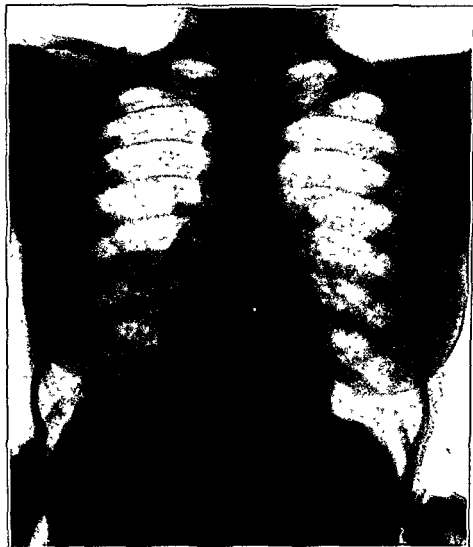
X-ray of the lungs of Case No. 1 shows considerable resolution of the exudative tuberculosis in the lower half of the right lung. Six and a half months have elapsed since the onset of the disease.
